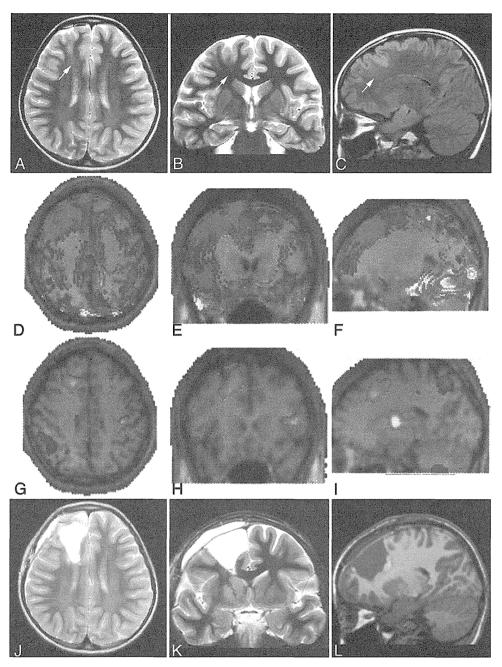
Case 6. A–C: Preoperative MR images showing blurring of gray matter—white matter in the right frontal lobe and the transmantle sign, that is, signal abnormalities extending radially inward toward the lateral ventricle from the cortical surface (arrows). D–F: 1231-iomazenil SPECT scans revealing low uptake at the right frontal lobe. G–I: Ictal SPECT scans showing significant hyperperfusion in the white matter of the right frontal lobe. J–L: Postoperative MR images obtained after resection of the right frontal lobe and the periventricular white matter.
